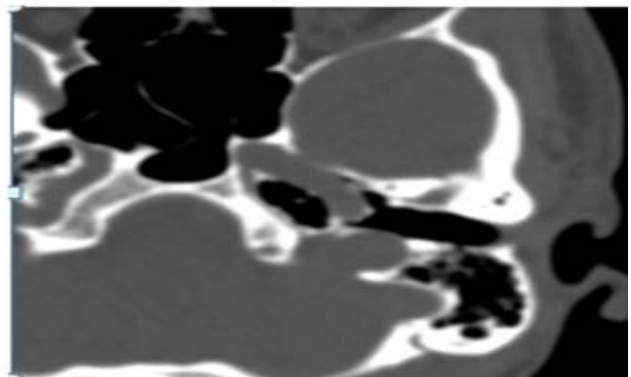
Axial HRCT image shows Large left jugular bulb and deficient sigmoid plate allowing the jugular vein to almost protrude Into the middle ear s/o Left side Dehiscent jugular bulb
